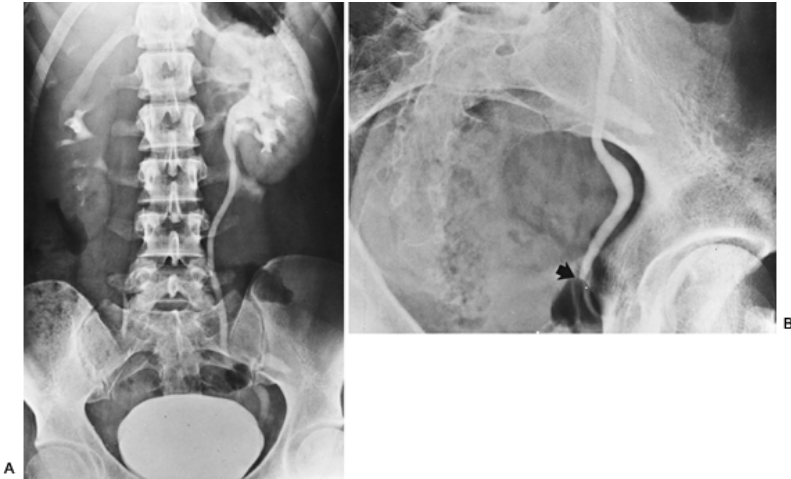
22. A: Two-hour radiograph in a patient with left-sided renal colic. There is dilation of the left ureter down to the level of the bladder. The point of obstruction is not demonstrated. Note the peripelvic extravasation of contrast resulting from fornix rupture. B: Postvoid radiograph in the left posterior oblique projection demonstrates the level of obstruction (*arrow*) due to a uric acid stone.
